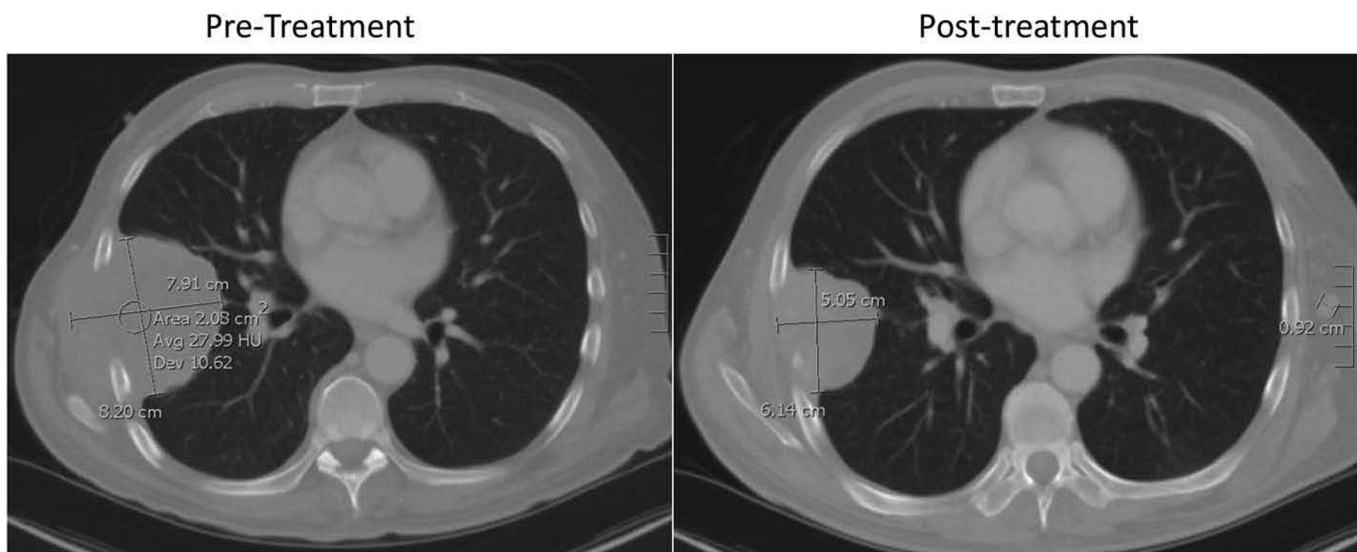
Pre- and post treatment CT scans.
